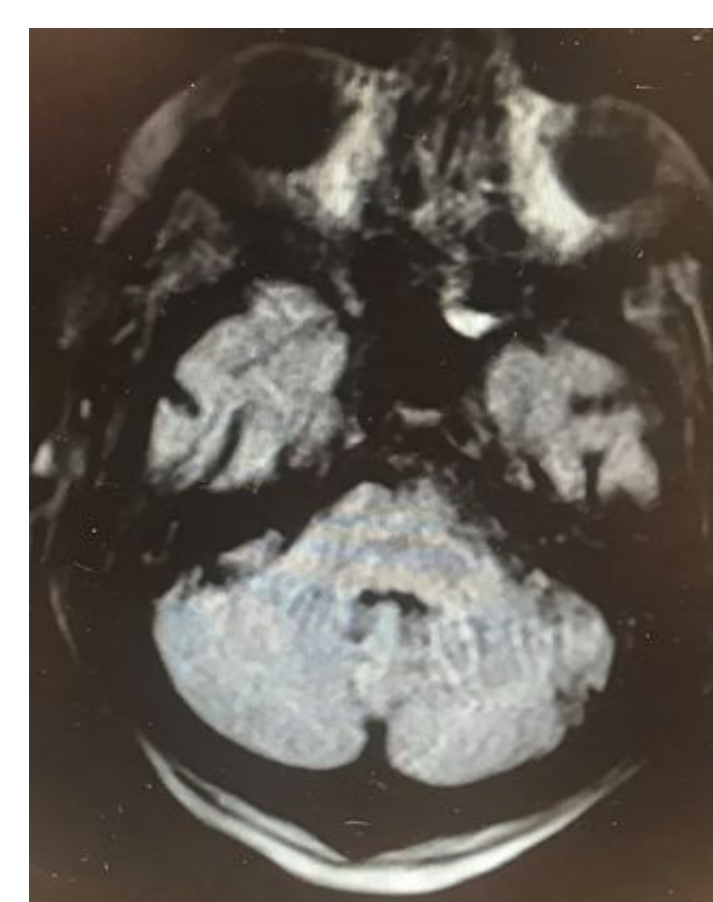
Axial MRI FLAIR image showing improvement of the hyperintensity in the medulla.
